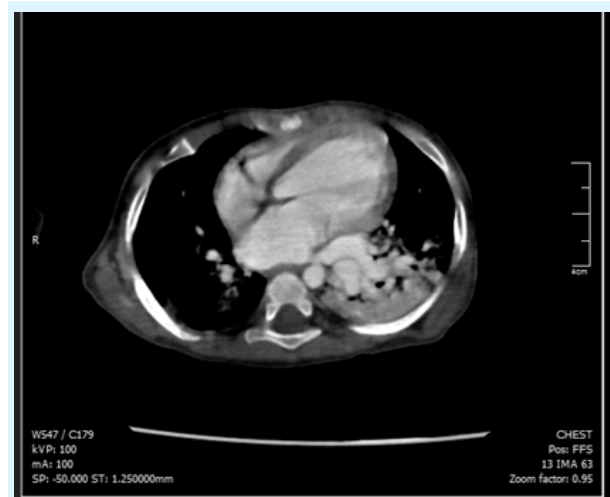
CT scan showing venous drainage of the systemic artery to the left inferior pulmonary vein
